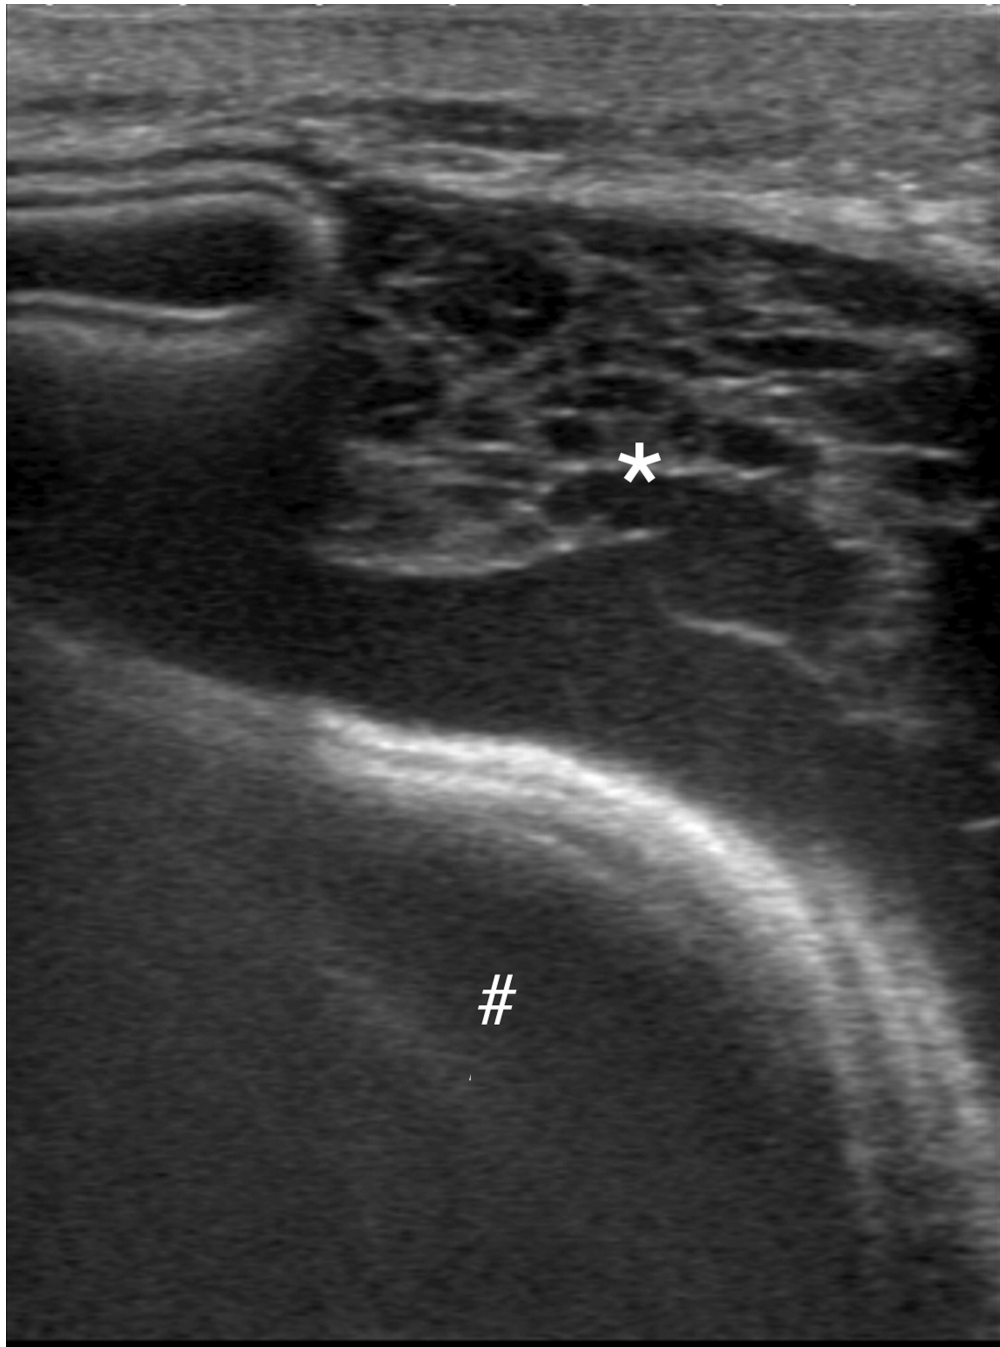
Ultrasound images of breast fluid collections. (a) Breast fluid collection (*) either abuts a fold in a non-fully inflated tissue expander versus partially deforms the expander (#). (b) Breast fluid collection (*) with septations.
